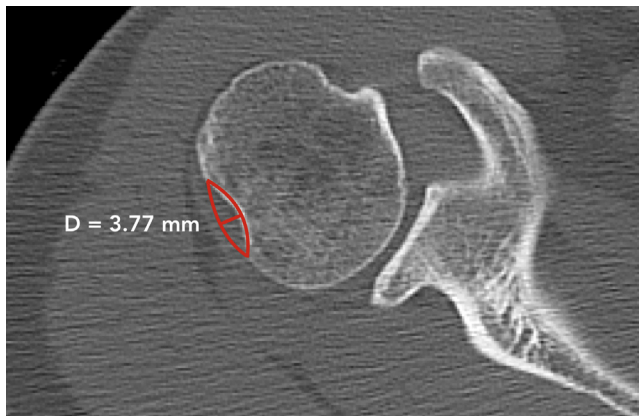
Axial view of a preoperative 2-dimensional computed tomography scan of a left shoulder demonstrating a Hill-Sachs lesion. Depth of the Hill-Sachs lesion was measured as the largest width of the bony defect visible on axial computed tomography (red line). This measurement was used along with the length and width measurements to calculate total Hill-Sachs lesion volume.
